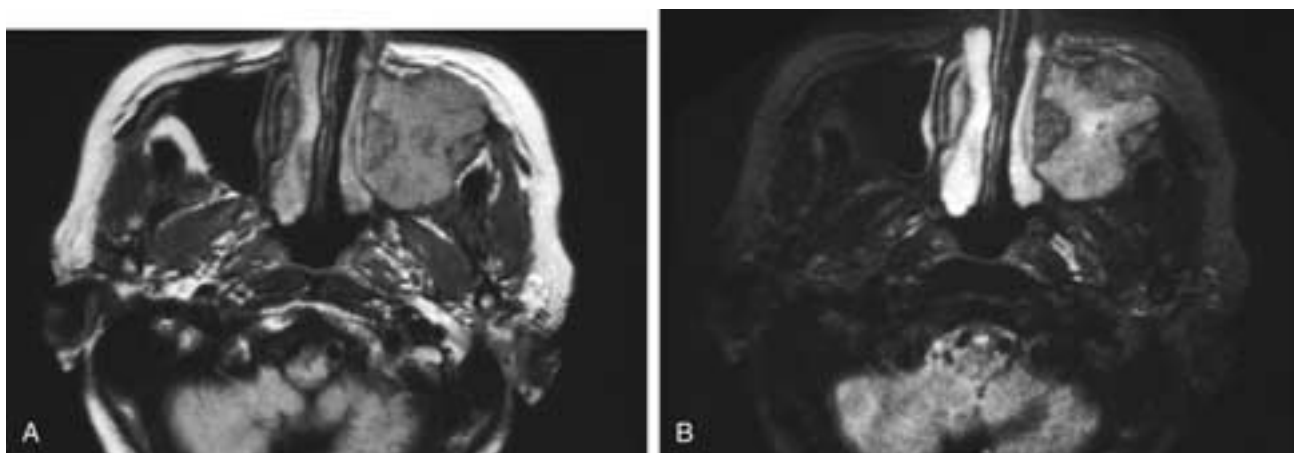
Axial T1-weighted (A) and T2-weighted (B) MR images show a destructive lesion in the left maxillary sinus that extends into the left infratemporal fossa and left cheek. The tumor has an intermediate signal intensity on both images but appears to brighten on the T2-weighted image. This is typical of most cellular tumors. Note that the tumor does not have as high a T2-weighted signal intensity as the turbinates or the inflamed mucosa along the medial wall of the right antrum. Such tumors almost never have a signal intensity that is lower on T2-weighted images than on T1-weighted images. This patient had a squamous cell carcinoma.
